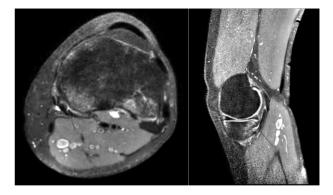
Magnetic resonance imaging sections with different lesions of the semimembranosus muscle. T2-weighted axial section with capsular lesion of the semimembranosus muscle (left). T2-weighted sagittal section with lesion of the distal insertion of the semimembranosus muscle (right).
